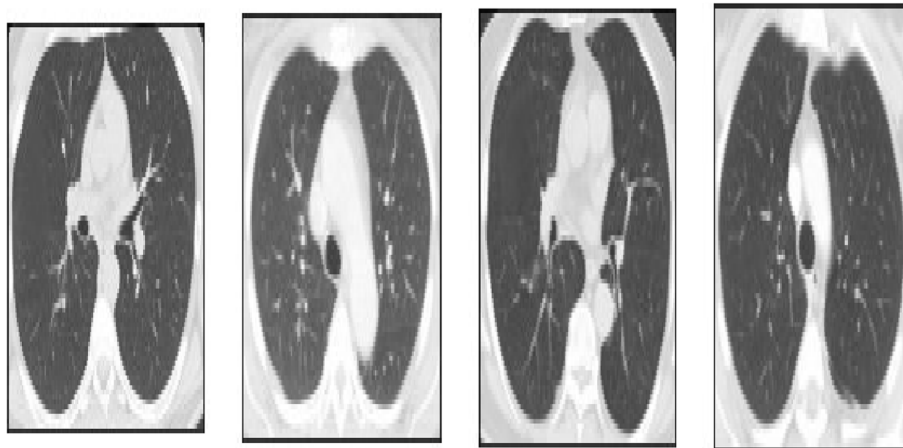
Non-COVID-19 Disease Images of CT-Scan
